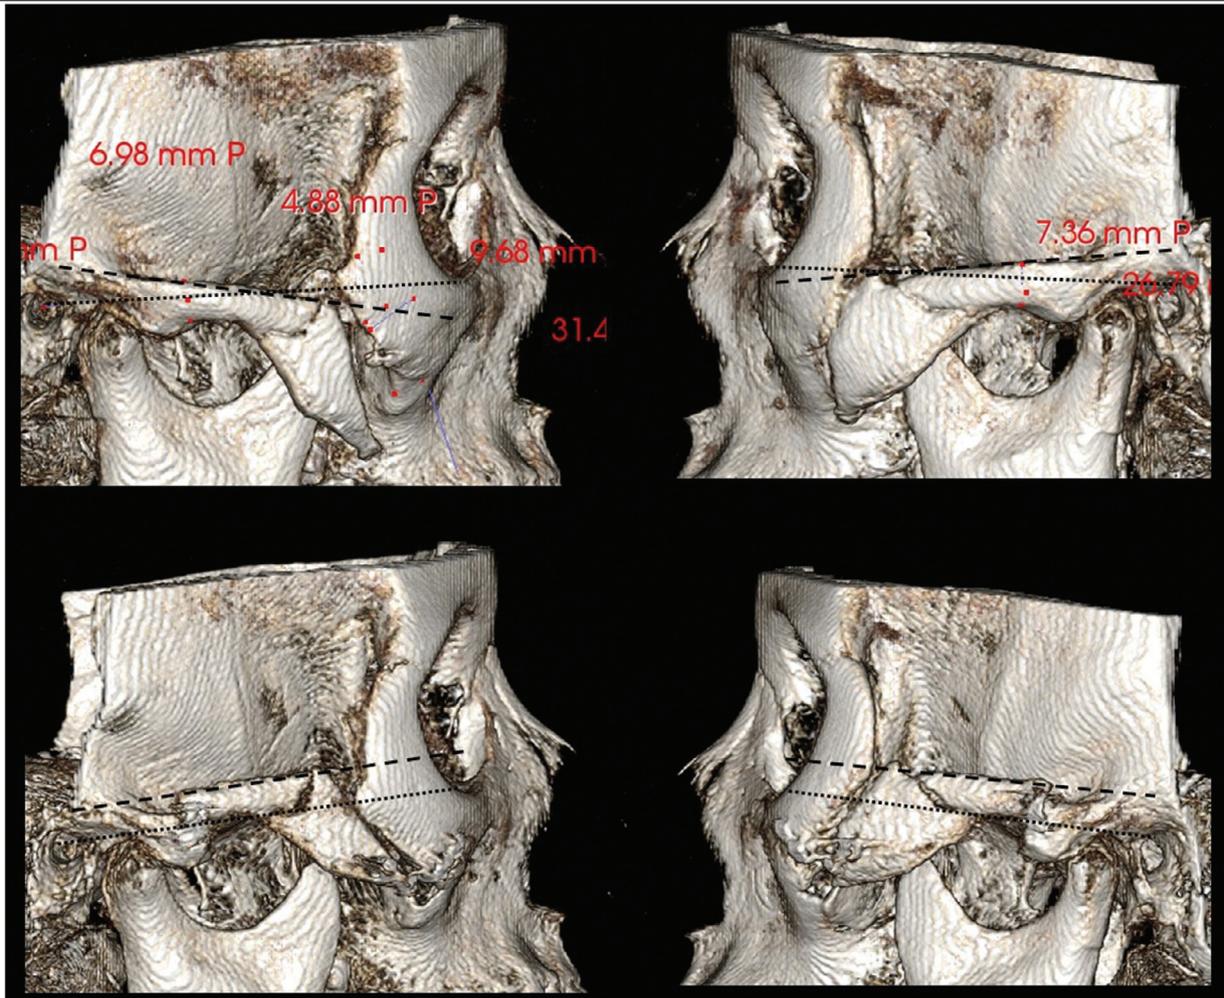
We performed asymmetric procedures in 24 patients who presented dissimilar bony malposition on the left and right sides. An appropriate combination of our techniques was applied to achieve bony union and symmetric outcomes. For objective analysis of pre- (top) and postoperative (bottom) states, the angle between two lines was measured: Frankfort horizontal line (dotted line) - upper border line of the zygomatic arch (dashed line). The difference of angles on both sides was calculated, and a comparative analysis was performed using pre- and postoperative facial bone 3D CT images.
